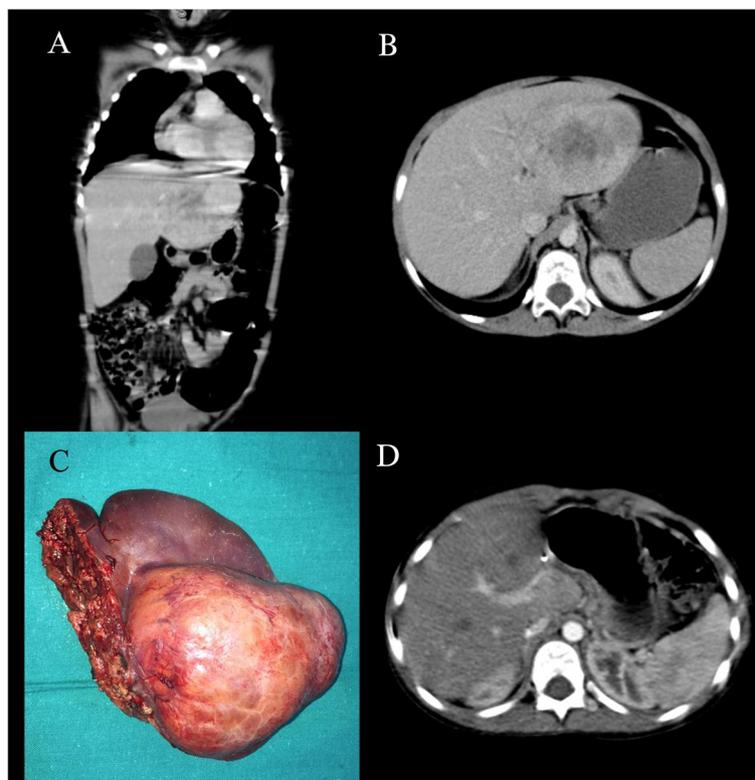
A Initial CT (coronal view) shows an adenoma in segment III (7.5 cm). B Initial CT (axial view) of the same patient. C Segmental resection was performed with complete tumor resection. D Postoperative CT after 3 months (axial view) shows clear operative bed
